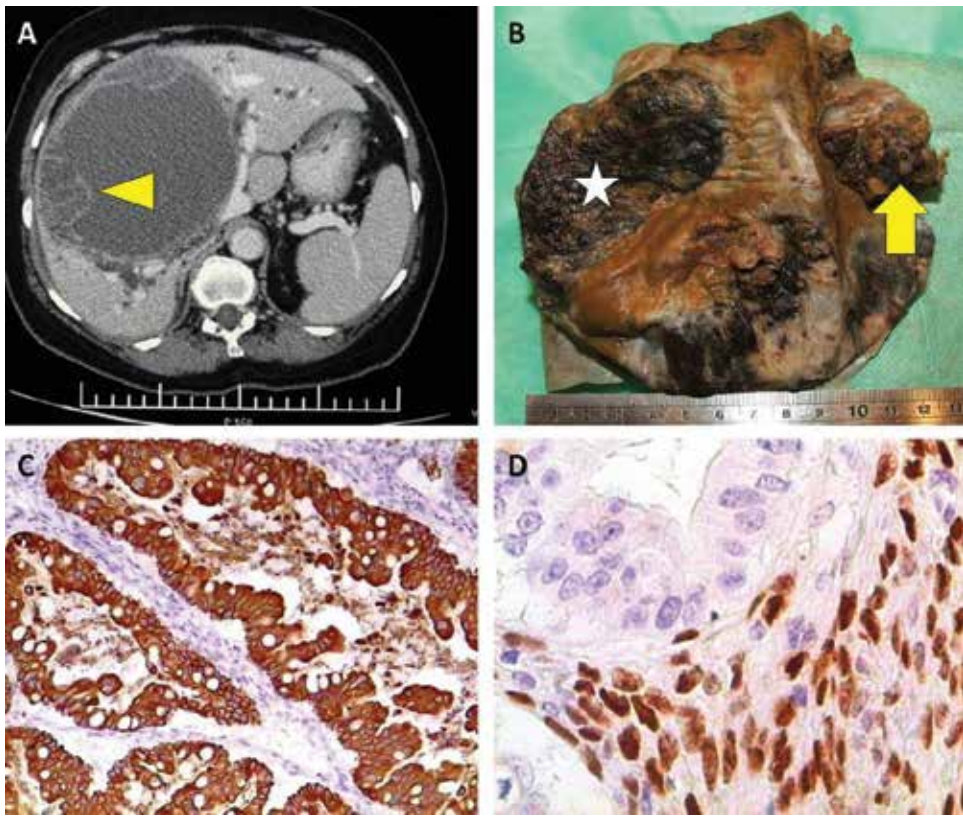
Mucinous cystic tumour of the liver. A, computed tomography findings. Note the huge cyst with internal septations (arrowhead). B, gross view. Note the nodule (arrow) harbouring invasive malignancy. Widespread haemorrhage (star) also is present. C, intense expression of cytokeratin 20 in an area of intestinal differentiation, showing rich presence of goblet cells. Immunoperoxidase (IP), original magnification (OM) 100 \times . D, Intense nuclear expression of progesterone receptors in the ovarian-type stroma. Note the absence of reactivity in the epithelium. IP, OM 400 \times .
